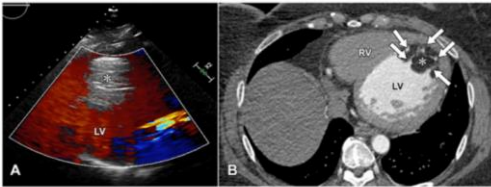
(A) Color Doppler mode transthoracic echocardiogram shows a large hyperechoic mass [M] measuring 20.4 cm<sup>2</sup>, occupying almost half of the left ventricular (LV) cavity. (B) Cardiac CT angiogram demonstrates dilated LV with a large, nonenhancing fat-attenuation mass [M] measuring 6.0 X 5.7 X 3.3 cm and with an attenuation of -110 to -87 H.U. The mass is multilobulated, with blood pool contrast agent insinuated in between the lobulations [arrowed]. No foci of calcification or necrotic component are seen. RV = right ventricle.
